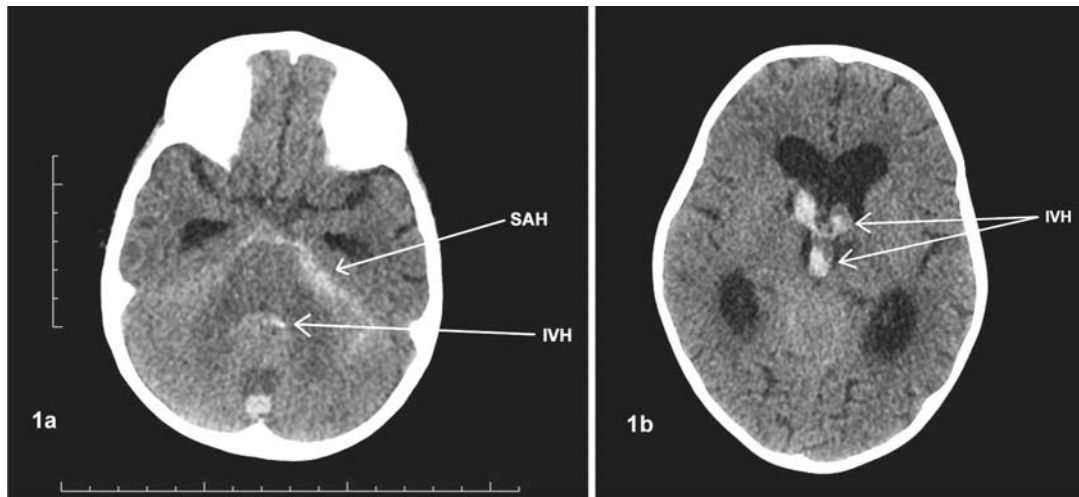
Non-contrast axial CT scan of brain showing (a) subarachnoid haemorrhage in prepontine cisterns and hemorrhage within 4th ventricle; and (b) haemorrhage in 3rd and both lateral ventricles.
